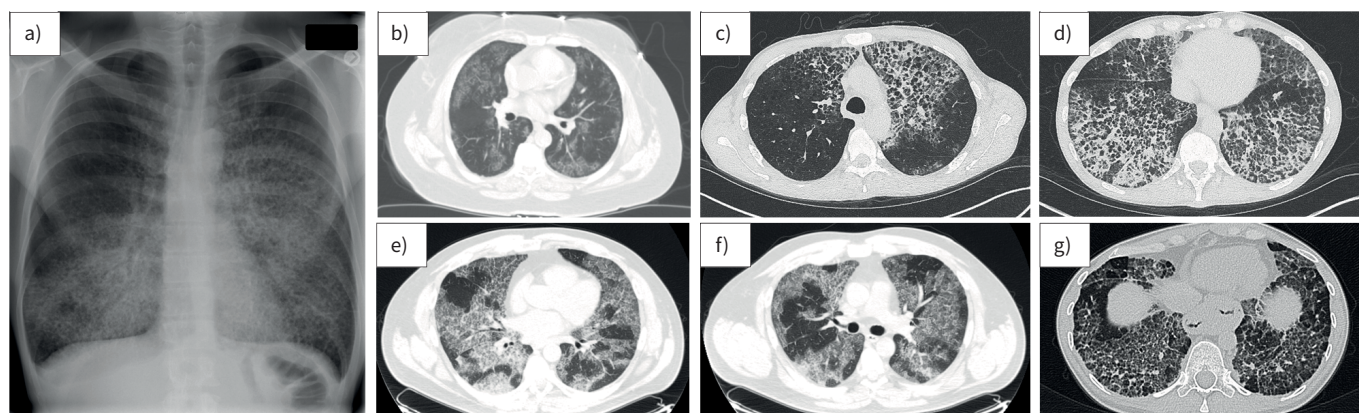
Radiological findings in pulmonary alveolar proteinosis (PAP). Representative images from a) chest radiography and b–g) computed tomography (CT) of the thorax demonstrating the diversity of radiographic findings in PAP. b) Ground-glass infiltrates in a mild case of autoimmune PAP (aPAP) without interlobular septal thickening. c–f) CT images demonstrating varying degrees of involvement with the distinctive pattern of interlobular septal thickening superimposed on ground-glass opacification, referred to as “crazy paving”. c, e, f) Clearly demarcated differences in the degree of involvement between adjacent lobes. g) aPAP complicated by pulmonary fibrosis 15 years after initial diagnosis of aPAP: CT demonstrates parenchymal distortion, honeycombing and traction bronchiectasis.
